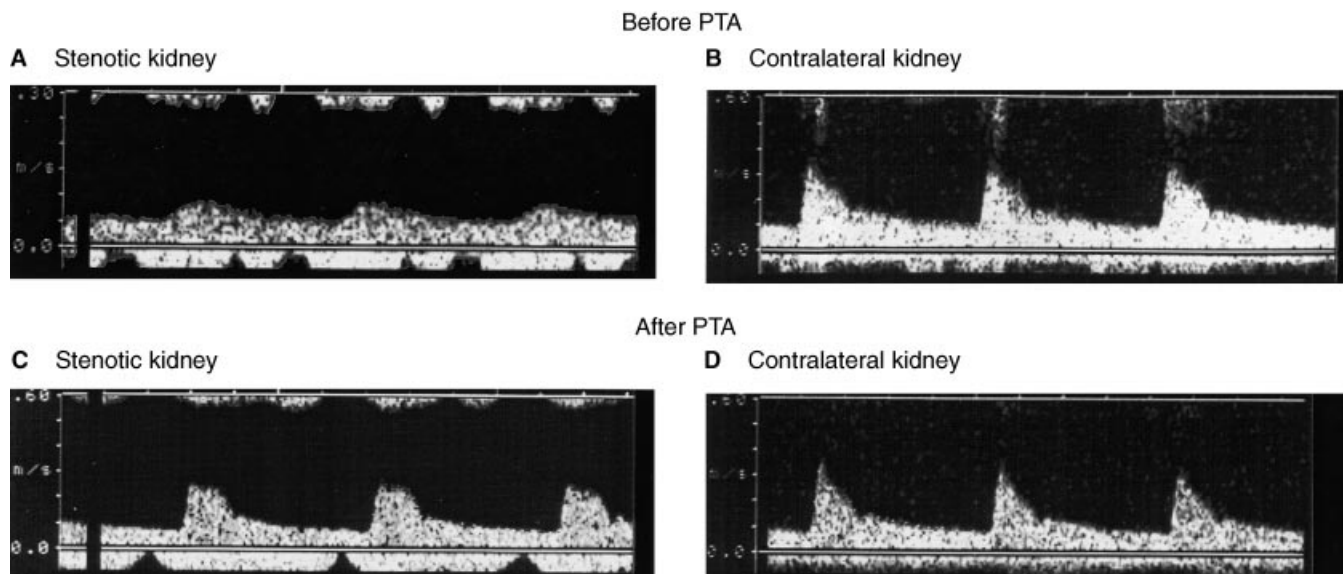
Doppler velocity spectra registered downstream from the stenotic lesion within the interlobar renal artery in a stenotic (A and C) and the contralateral kidney (B and D) before (A and B) and one day after (C and D) percutaneous transluminal angioplasty (PTA). Both acceleration of the blood flow during early systole and the pulsatility index (PI) were reduced within the stenotic kidney compared with the contralateral kidney. After PTA, both acceleration and PI within the stenotic kidney increased.
